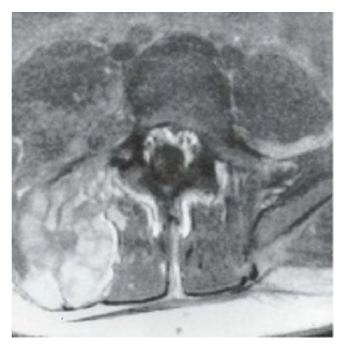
Neurofibromatosis in a 16-year-old patient. The MRI at the level of L4–L5 demonstrates a large plexiform neurofibroma that invades the neural axis. It extends from the level of L3 to the sacrum.
